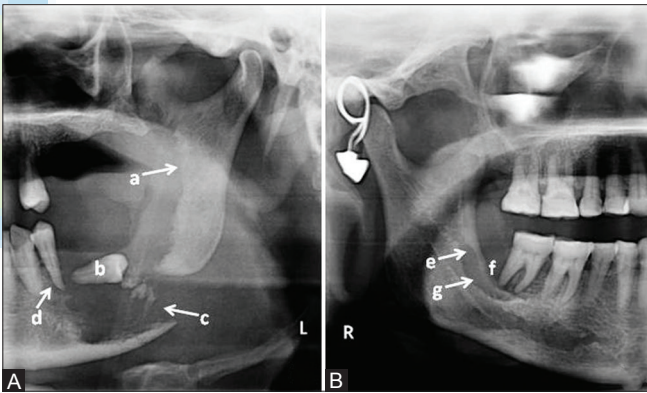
(A and B) Panoramic radiograph showing (a) ragged margins; (b) floating tooth; (c) pathologic fracture; (d) spiking of the root; (e) smooth margins; (f) saucerization; (g) invasion of inferior alveolar nerve canal
